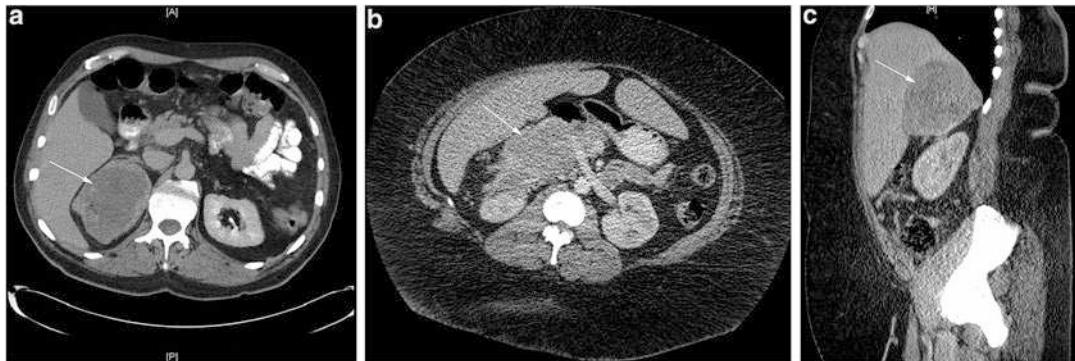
Adrenal cortical carcinoma. (a) CT image of a right adrenal cortical carcinoma in the axial plane with central necrosis (arrow). (b) Right adrenocortical carcinoma (arrow) with irregular margins causing duodenal
